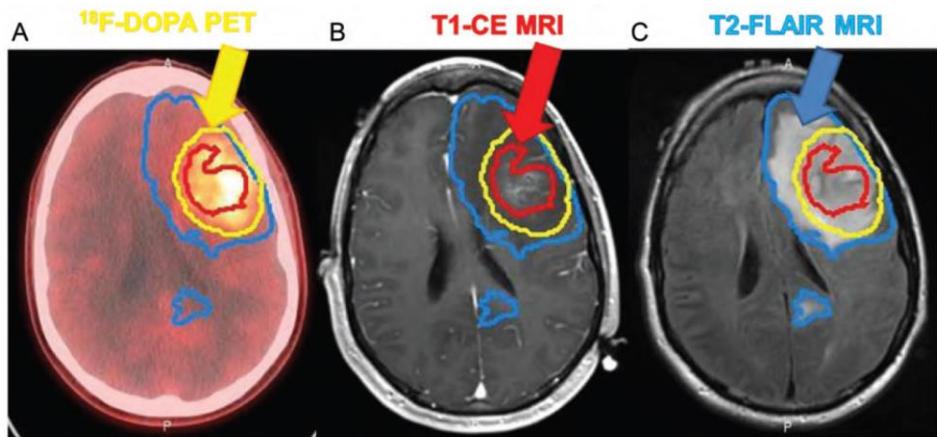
Registered <sup>18</sup>F-DOPA PET-CT (A), T1-CE MRI (B), and T2-FLAIR MRI (C) contours drawn by the neuroradiologist and the <sup>18</sup>F-DOPA representing the region of high-grade disease components defined by T/N > 2.0.
